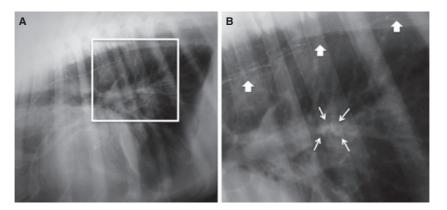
Four-week postprocedure lateral thoracic radiograph of Case 1. (A) A white square marks the area magnified in 3B. (B) Notice the radio-opaque glue embolus present in the pulmonary vasculature (thin arrows) as well as the persistent radio-opaque glue mixture seen in the thoracic duct branches (block arrows).
